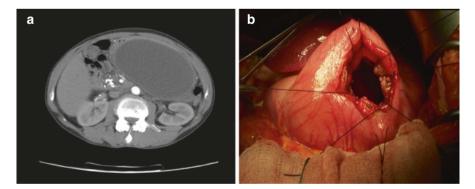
(a) Multi-detector computed tomography scan image depicting a chronic pseudocyst. Calcification is seen in the head of the pancreas. (b) Operative picture of a wide surgical cystogastrostomy
